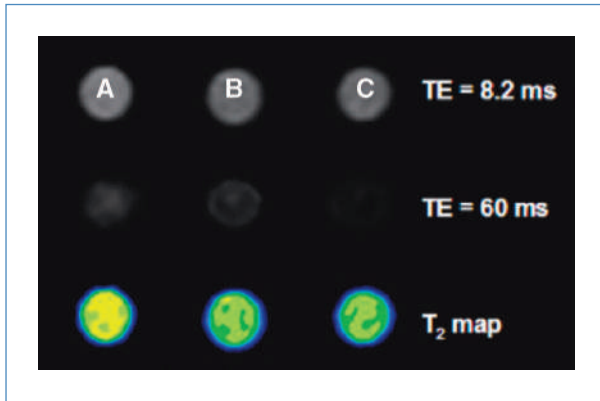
Binding of EGFRvIIIAb-IONPs to human glioblastoma cells and MRI contrast enhancement. The binding of EGFRvIIIAb-conjugated IONPs to human GBM cells that overexpress the EGFRvIII mutated protein was confirmed by MRI contrast changes (lower signal intensity at longer TE in T₂-weighted imaging and reduction of T₂ values as shown in Table 1B and C after 1 and 2 h of treatment) when compared with the control samples of free IONPs (A).
